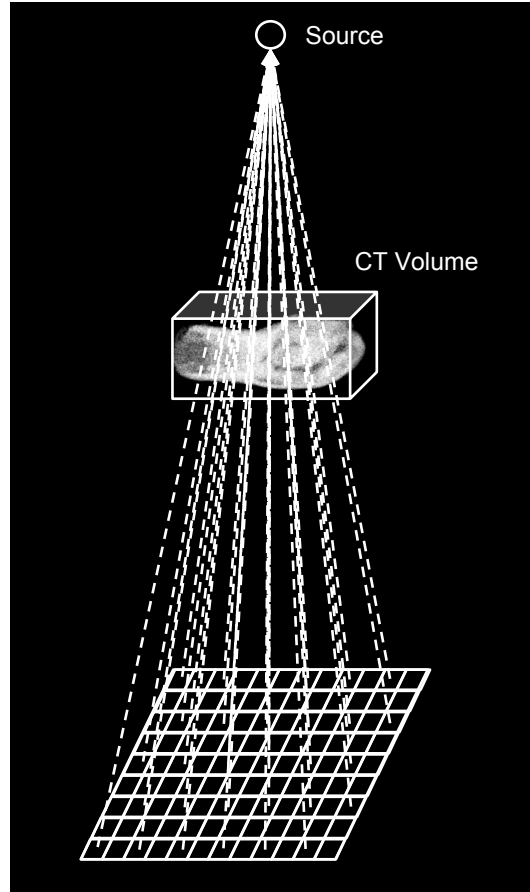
DRR generation via raycasting. Line integrals through a CT volume are computed at each pixel.
